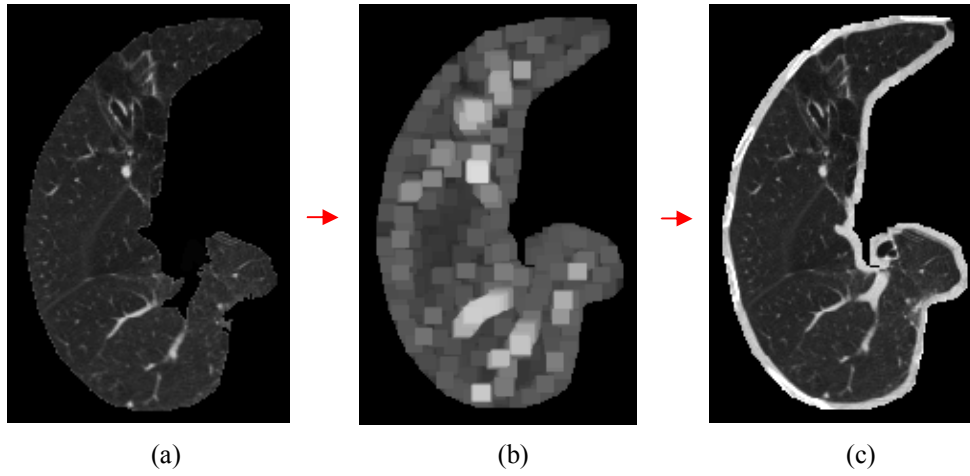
(a) Lung regions after flood fill and CT background removal operations (b) Result of applying the dilation mask four times (c) Dilated lung regions shown by original pixel intensity
